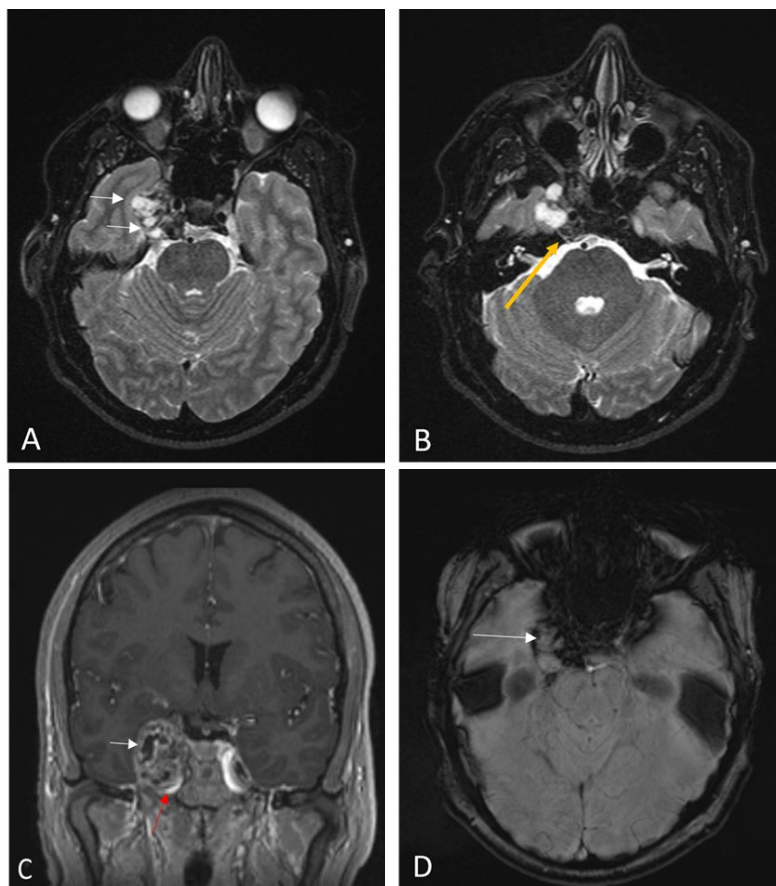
Preoperative MRI of the skull base. Axial T2 weighted (A, B), Coronal MPRAGE post contrast T1 (C) and Axial SWI (D) images demonstrate a mixed signal, predominantly a hyperintense T2 heterogeneously enhancing mass (white arrows) in the right parasellar region involving the cavernous sinus and the Meckel's cave (white arrows). The cavernous carotid artery is narrowed (red arrow). Mass extends posteriorly to the petroclival synchondrosis (yellow arrow), which is intact. SWI sequence demonstrates underlying foci of susceptibility consistent with calcification (long white arrow).
